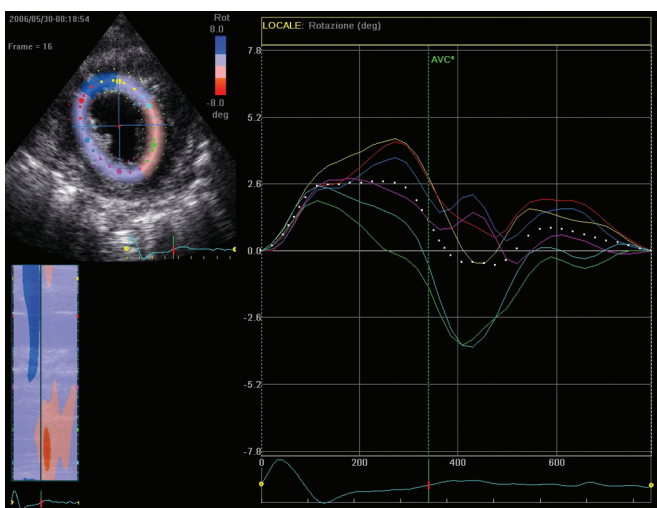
Left ventricular systolic-rotation movement studied by 2-dimensional speckle tracking echocardiography. Short-axis apical level, 11 days after the modified surgical anterior ventricular restoration aimed at realigning residual myocardial fibers.
